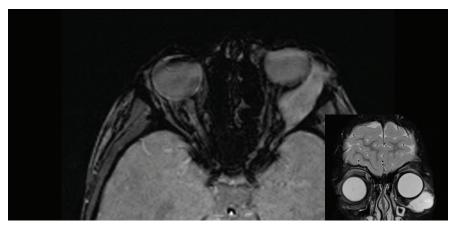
MRI of an infraorbital rhabdomyosarcoma with posterior extension in the patient's left eye. Note the globe displacement.
